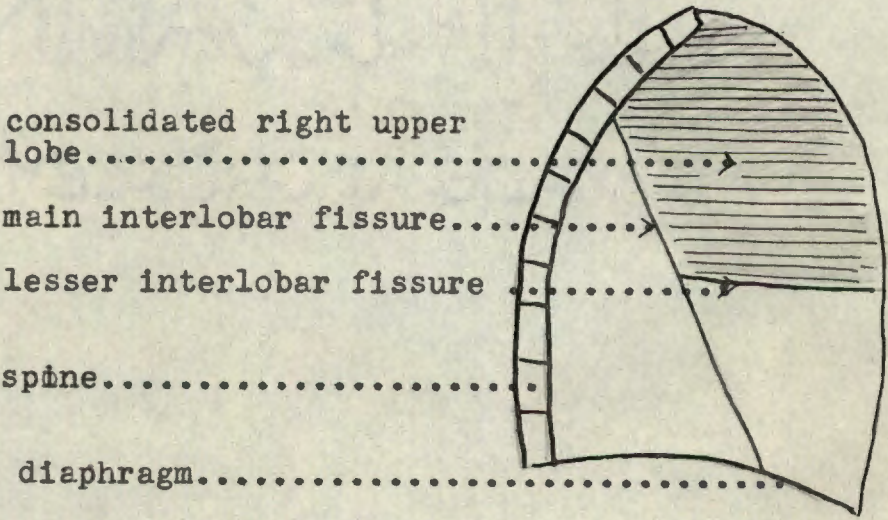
Lateral radiograph of chest (same case as fig. 27) with consolidation of the right upper lobe. The upper part of the main fissure and whole length of the lesser fissure play a part in the delineation.
